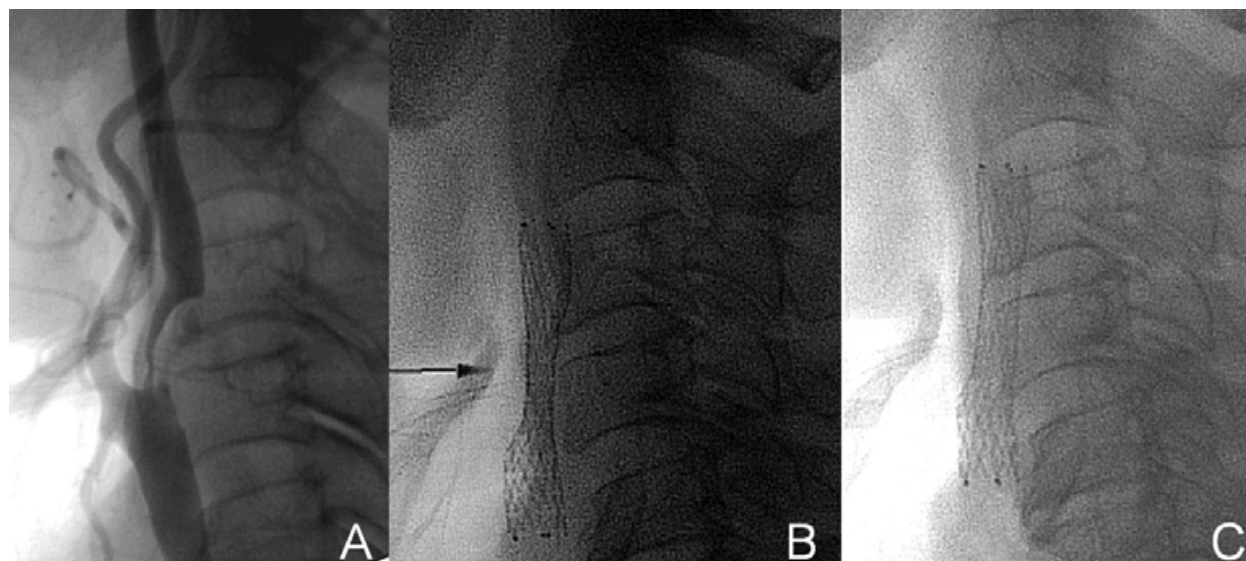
A 78-year-old patient with severe aortic valve insufficiency and chronic obstructive pulmonary disease who exhibited an episode of amaurosis fugax of the right eye. Angiography showed severe (80%) right internal carotid artery stenosis (A). A 7 X 40 mm self-expandable stent (arrow) (Protégé®, eV3 Inc., Plymouth, Minnesota, USA) for stenting without balloon angioplasty; the immediate result after placement of the stent showed a small residual stenosis of about 30% (b). Lateral radiography 1 month later (C) showed complete expansion of the stent.
